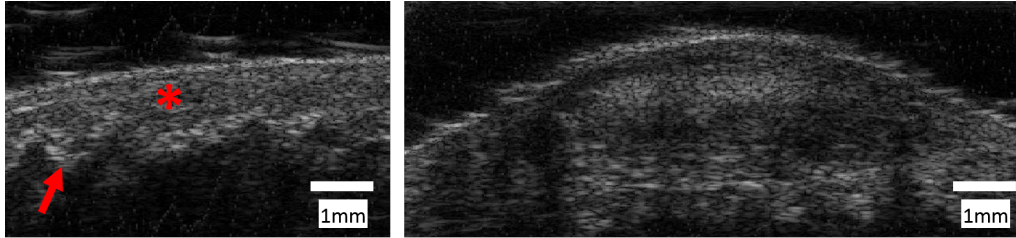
Ultrasound observation of healthy skin (left) with regular dermis+epidermis and hyper echogenic layer marked with a red asterisk, as well as clear identified border with dark hypodermis indicated with a red arrow; and keloid scar (right) characterized by ovoid shape without distinction of the different layers.
